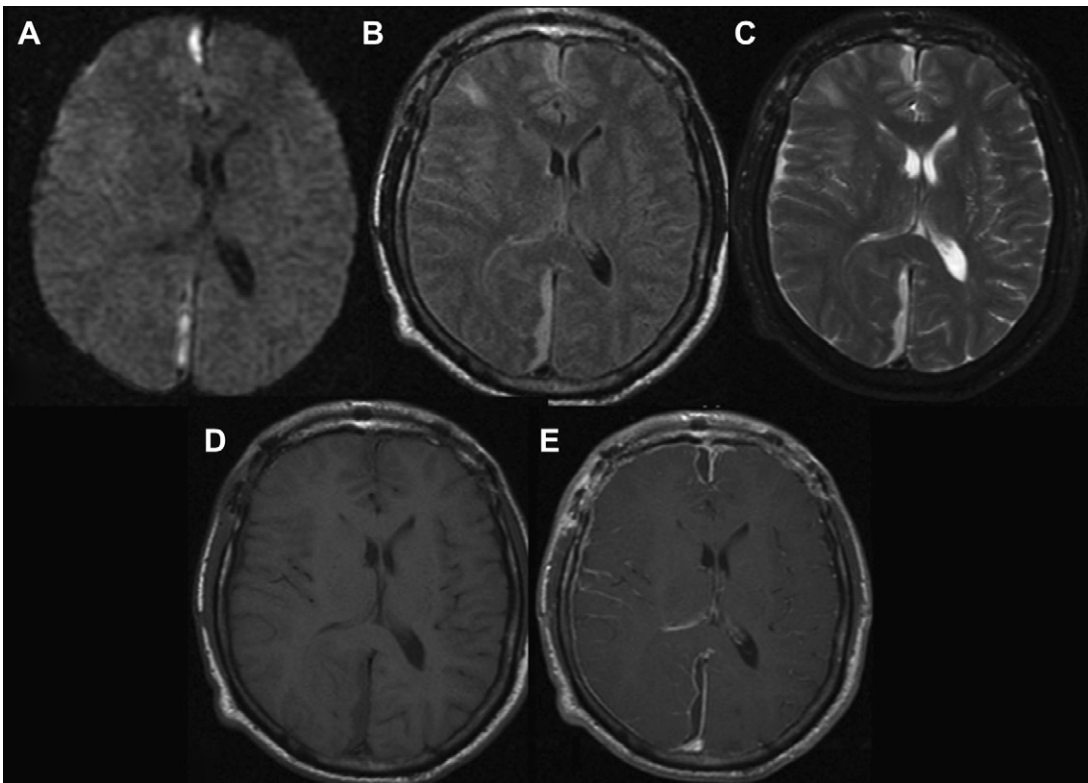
Subdural empyema in a 34-year-old woman. Axial T2WI (B) and FLAIR imaging (C) shows concavo-convex hyperintense collection abutting anterior and posterior interhemispheric fissure, with presence of focal cortical hyperintensity in right frontal lobe. Collection is hypointense on T1WI (D) and showing restriction on axial DWI (A). Peripheral enhancement is seen on axial postcontrast T1WI (E), along with the presence of increased leptomeningeal enhancement.
